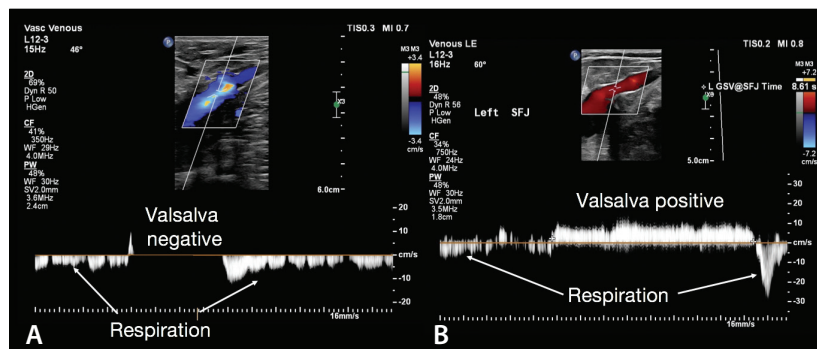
Normal (A) and abnormal (B) Valsalva maneuver results. Pulsed-wave Doppler: normal response to Valsalva, no flow with exertion (A) and abnormal response to Valsalva, reverse flow above baseline (B).
